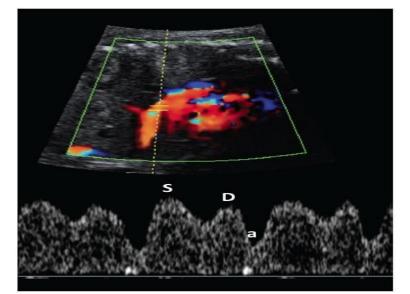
Color Doppler Imaging of the Ductus Venosus (DV) and a Normal Second-Trimester DV Waveform.
